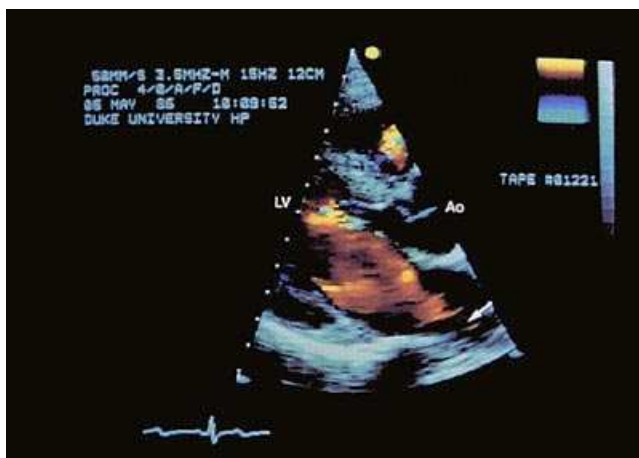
22 Left parasternal long-axis view of blood emerging from a pulmonary vein (arrow) and filling the mitral valve orifice. An enhanced map was used.
